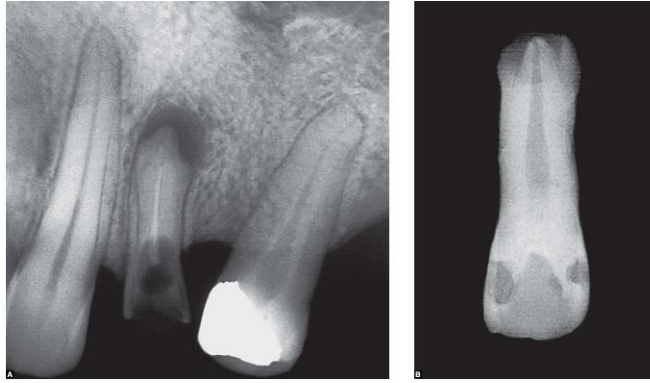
Upper premolar and incisor with hypercementosis in shape of a «shirt sleeve cuff». This aspect is provided by the presence of chronic periapical lesion and increased formation of reactive nature in the periodontal periphery of the lesion.
